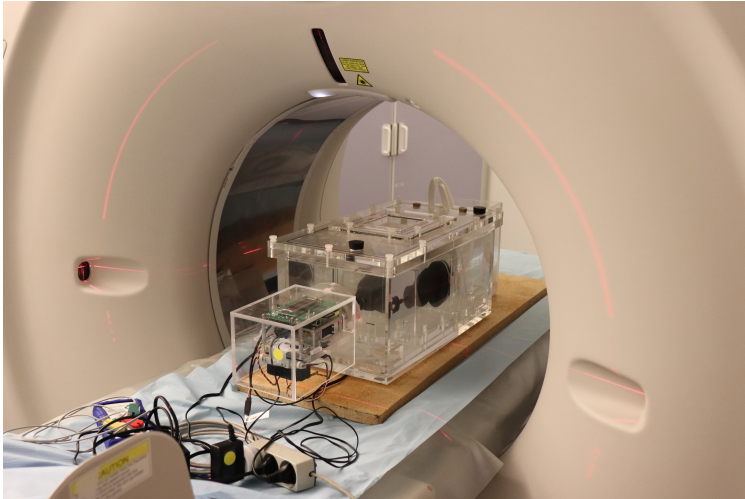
DHP in CT scanner at Rigshospitalet, Denmark. Notably this acquisition was performed before the new DHP setup was designed (see 4.2.6).
